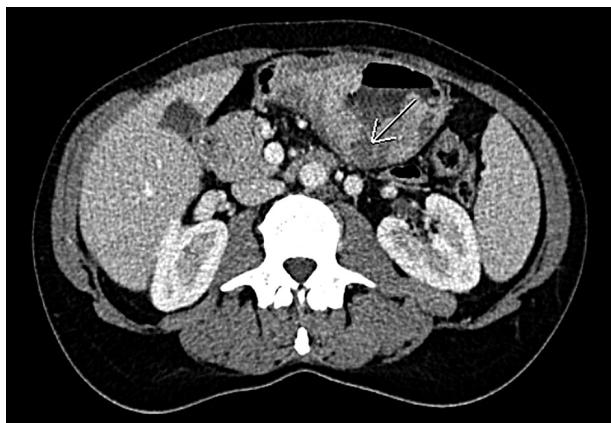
CT scan of the abdominal cavity showing the location of the tumor
